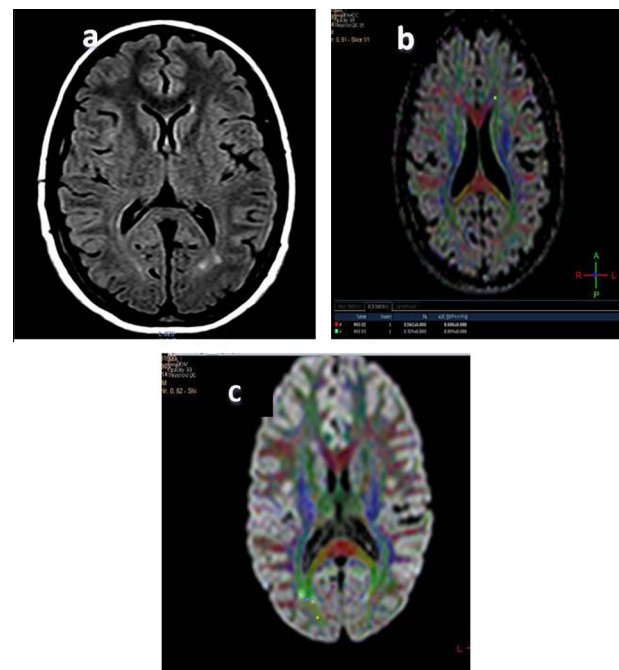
Female patient (37 years) (a) FLAIR MRI shows multiple hyperintense lesions in periventricular WM (b and c) color-encoded maps (red, left to right; blue, cranial to caudal; green, anterior to posterior).
